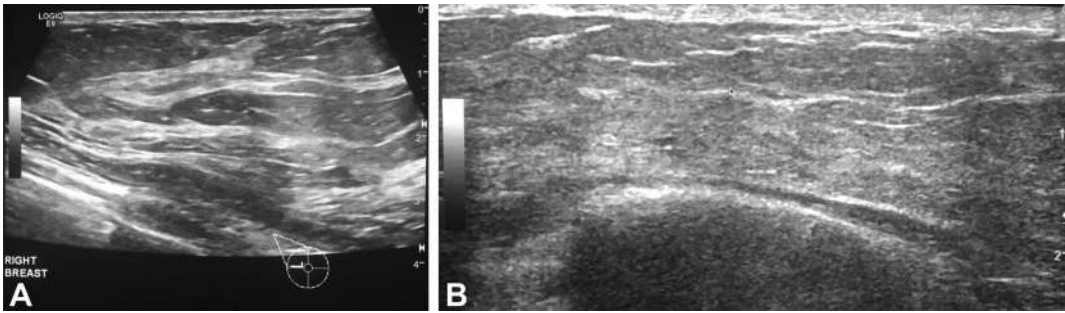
Screening breast ultrasonograms with normal results, 9 o'clock position of the right breast of the patient described in Fig. 1B. A. Baseline ultrasonogram 1 year before pregnancy (2017) demonstrates a mixture of mildly echogenic glandular tissue (*white*) and adipose tissue (*dark grey*). B. Ultrasonogram performed during lactation (2019). Nearly all of the adipose tissue has been replaced by mildly echogenic glandular tissue.
